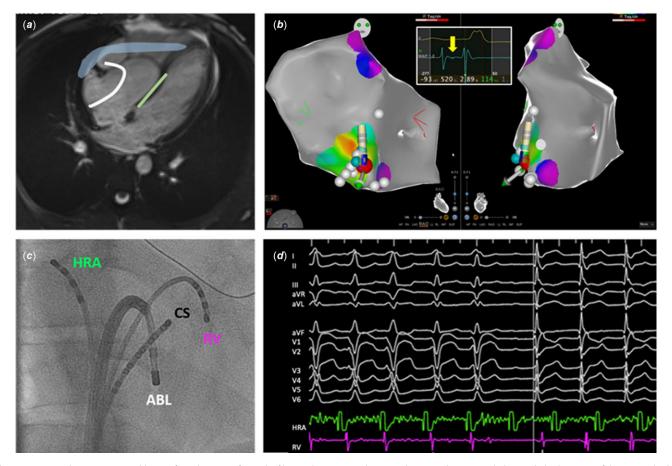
Ventricular insertion site ablation of a Mahaim atriofascicular fibre in Ebstein anomaly. *a*. MRI depicting Ebstein morphology with displacement of the tricuspid valve and atrialized ventricular area. White line – ablation catheter position; white shadowed area – suspected accessory pathway; green line – septal tricuspid valve annular displacement distance. *b*. Three-dimensional electroanatomical map. Yellow arrow – Mahaim potential on electrogram. White dots – Mahaim potential locations; pink dot – best Mahaim potential locations; and red dot – final ablation point resulting in persistent block within 8 s (35W, 47°C). *c*. Fluoroscopic right anterior oblique view depicting catheter positions with ablation catheter atrial catheter (fixed-shape quadripolar, 6F); RV = right ventricular apical catheter (fixed-shape quadripolar, 6F); RV = right ventricular apical catheter (fixed-shape quadripolar, 6F); RV = right ventricular nodal conduction only. HRA = high right atrial catheter; RV = right ventricular apical catheter.
